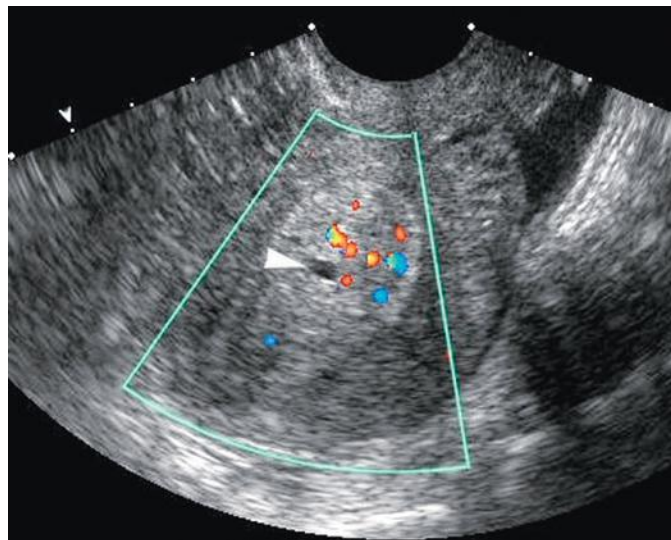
A 50-year-old woman with breast cancer on tamoxifen therapy with intermittent vaginal bleeding. Transverse color Doppler transvaginal sonographic image of the uterus shows endometrial thickening with internal cystic change (*arrowhead*) and diffusely increased vascularity. This appearance is nonspecific and may represent endometrial hyperplasia, polyp, or carcinoma, particularly in the setting of tamoxifen therapy. Although much less common, metastatic breast cancer can have this appearance. Endometrial biopsy was negative; however, the patient underwent hysterectomy with the goal of inducing surgical menopause prior to initiation of an aromatase inhibitor. Final surgical disease demonstrated poorly differentiated metastatic breast cancer.
